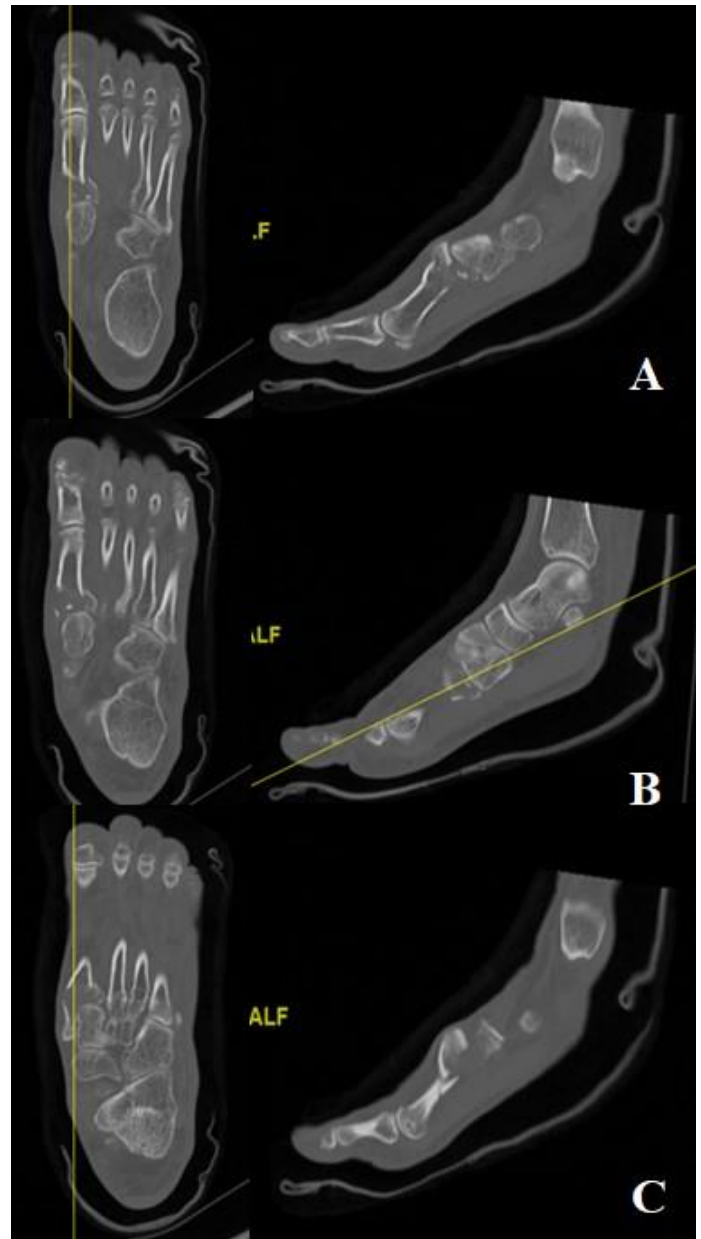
CT scan images of 3A to 3C showing the axial and its corresponding sagittal cuts of the 1st metatarsal base comminuted fracture with intraarticular extension. Image 3C depicts the avulsion fracture fragment on the dorsomedial aspect of the midfoot
